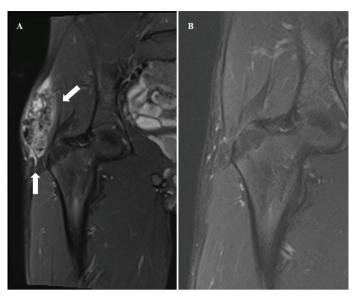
(A) Frontal plan magnetic resonance imaging showing soft tissue calcification around the right hip before the treatment (white arrows). (B) 3 months after topical STS and acetazolamide *STS: sodium thiosulfate*
